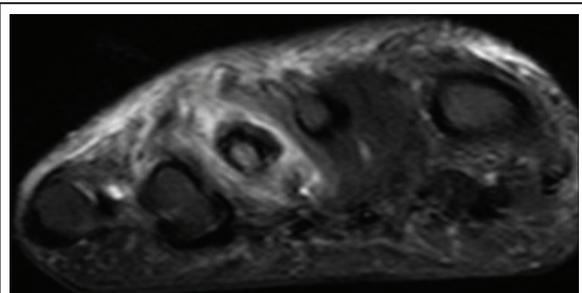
MRI – healing stress fracture 3rd metatarsal surrounded by edema.
